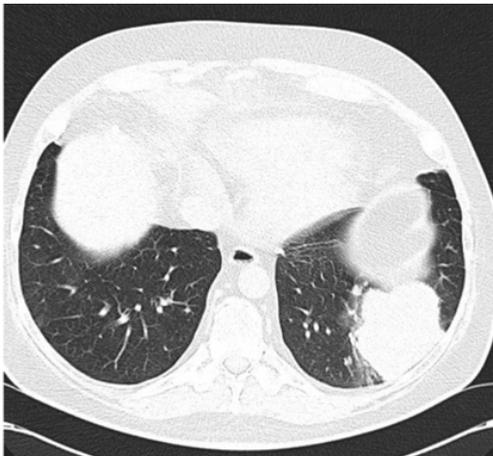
CT scan showing chest nodules. Image courtesy of Martin Hoenigl, MD.
